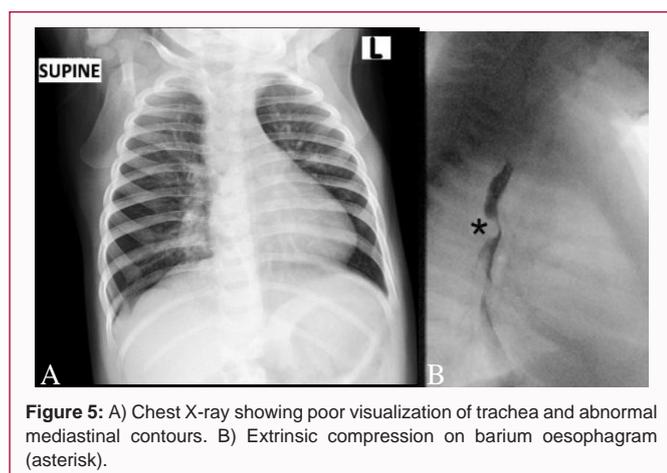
A) Chest X-ray showing poor visualization of trachea and abnormal mediastinal contours. B) Extrinsic compression on barium oesophagram (asterisk).
